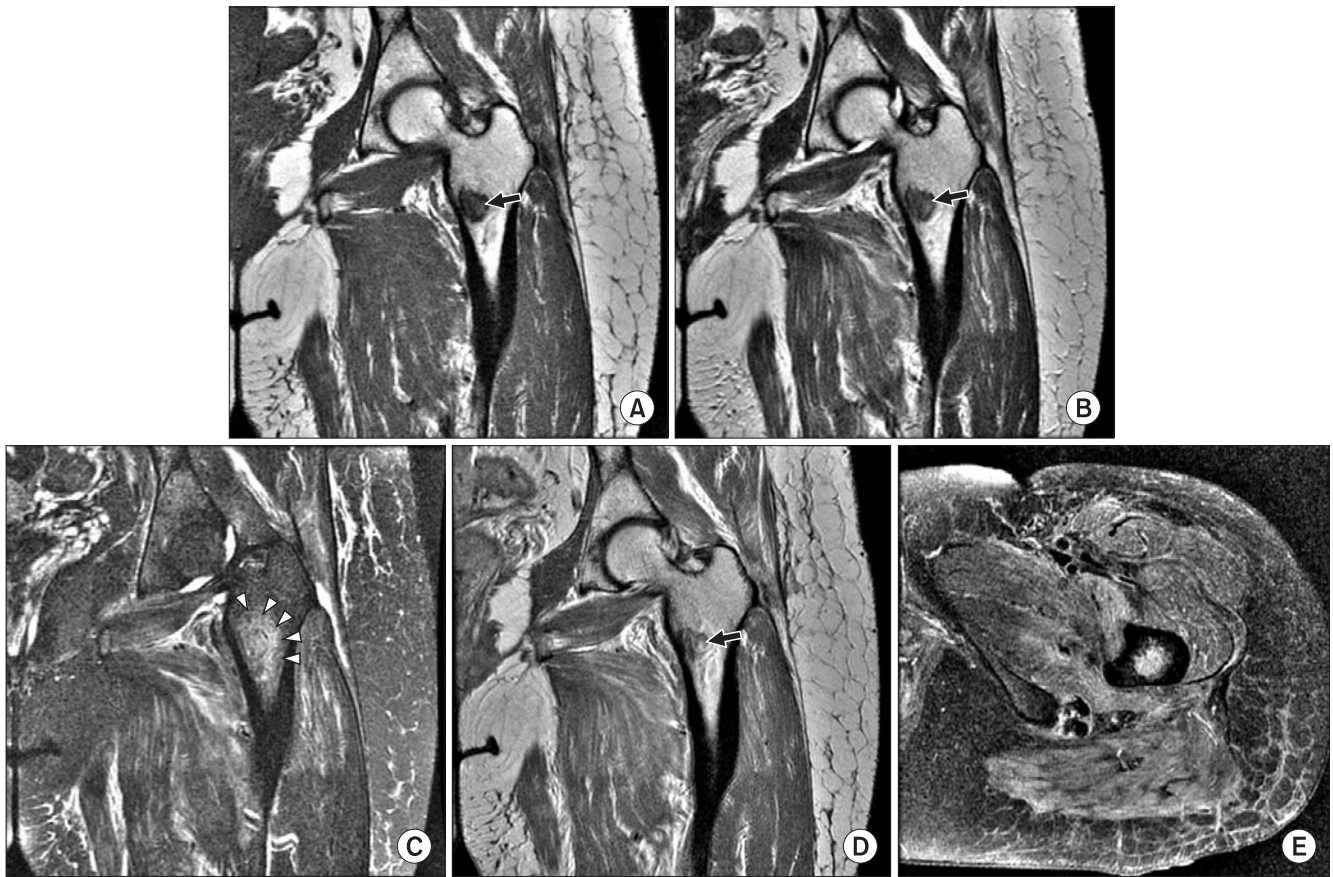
A 46-year-old woman who underwent MRI for intermittent left hip pain after radiation for one month. Left proximal femoral lesion was interpreted as a fibrous dysplasia based on MR findings. T1-weighted (A) and T2-weighted (B) coronal images show a well-defined hypointense lesion (arrows in A and B) in left proximal femur. Fat-suppressed T2-weighted coronal image (C) shows moderate perilesional hyperintense signal (arrowheads) on the left proximal femur suggesting post-radiation edema. Contrast-enhanced T1-weighted coronal image (D) shows mild contrast enhancement in the mass (arrow). Axial fat-suppressed contrast-enhanced T1-weighted image (E) also shows mild contrast enhancement in the mass. Adjacent muscles in the medial compartment of the thigh shows relatively well-demarcated contrast enhancement, suggesting post-radiation edema.
